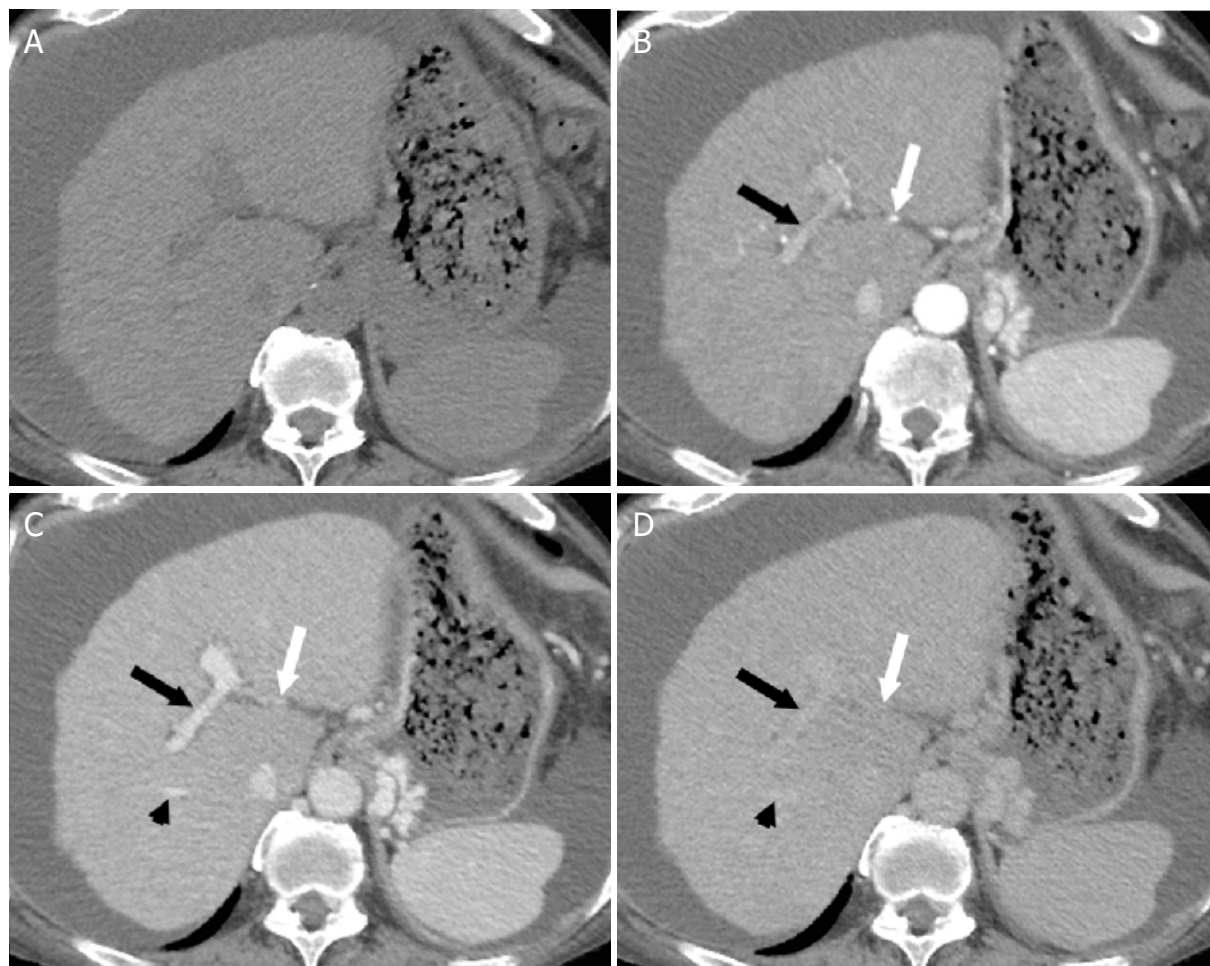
Dynamic Imaging for Evaluation for Hepatocellular Carcinoma. Axial CT images demonstrating the pre-contrast (A), hepatic arterial (B), portal venous (C), and delayed (D) post-contrast imaging phases. Pre-contrast imaging (A) is not required for HCC evaluation unless the patient has undergone local ablation that results in high attenuation material in the liver that may obscure enhancing lesions. The hepatic artery (white arrow) and portal vein (black arrow) demonstrate enhancement during the hepatic arterial phase (B). During the portal venous phase (C), the hepatic veins begin to enhance (black arrowhead). The hepatic veins, portal veins, and hepatic arteries demonstrate progressively decreasing enhancement during the delayed phase (D). HCC: hepatocellular carcinoma; CT: computed tomography
